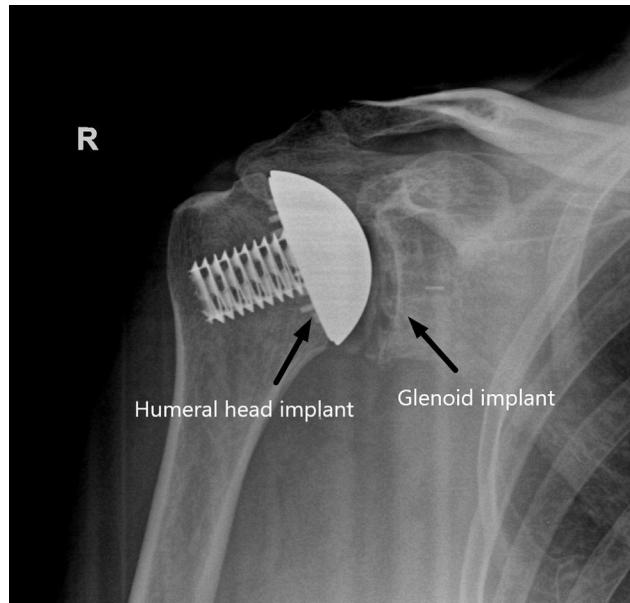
Postoperative follow-up radiograph (anteroposterior view) of the right (R) shoulder showing the intact stemless humerus implant and glenoid component with bony incorporation and without loosening.
